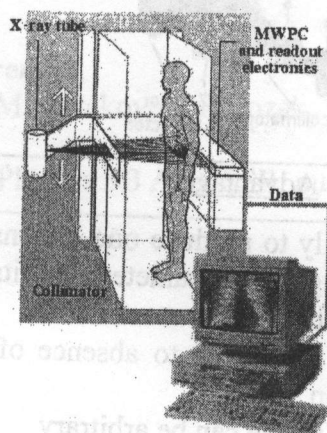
The installation for medical radiography
